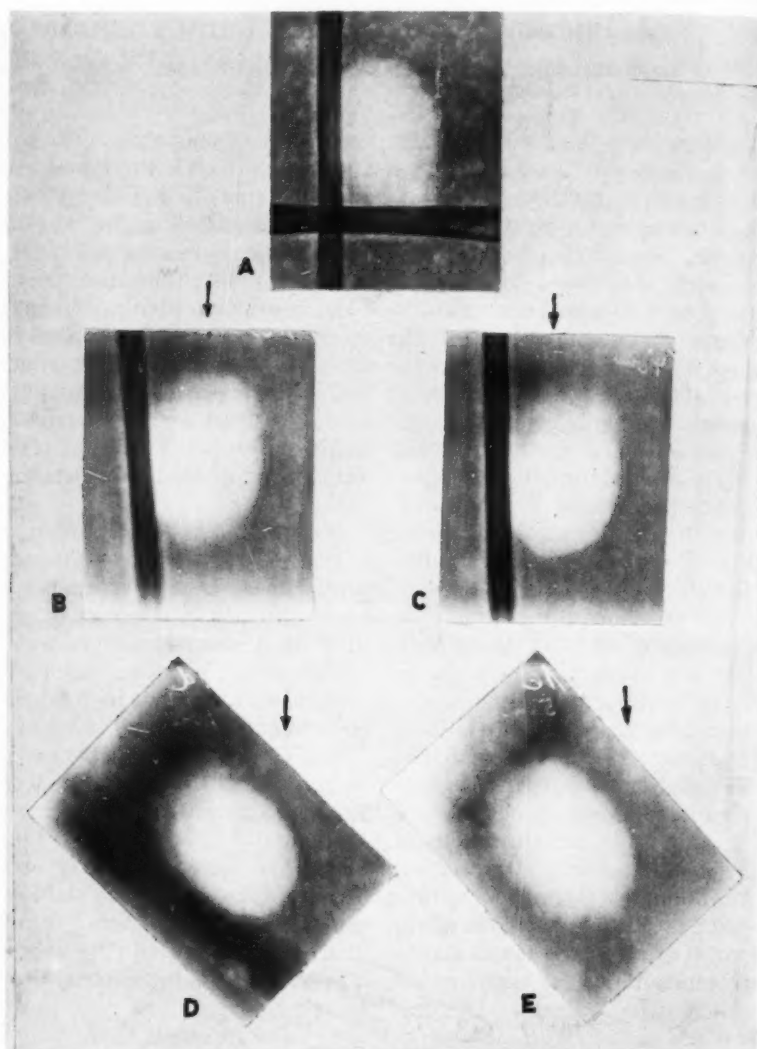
Experimental study with a paraffin block on top of which two bones were laid at right angles to each other. A. Routine roentgenogram. B and C. Tomograms—layers 4 and 5 cm. from the top, respectively—made with the tube shift in a direction parallel to the long axis of one of the bones. D and E. Tomograms of the same layers obtained with the block turned at an angle of 45° to the direction of the tube shift.
